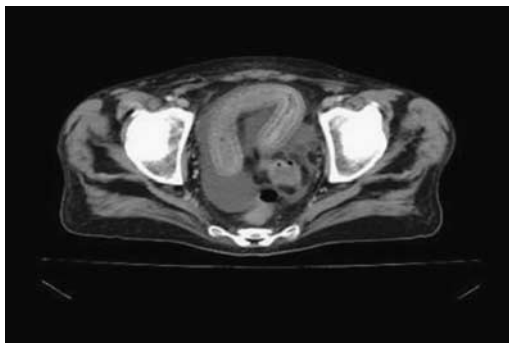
CT showing diffuse concentric thickening of the small bowel wall.
